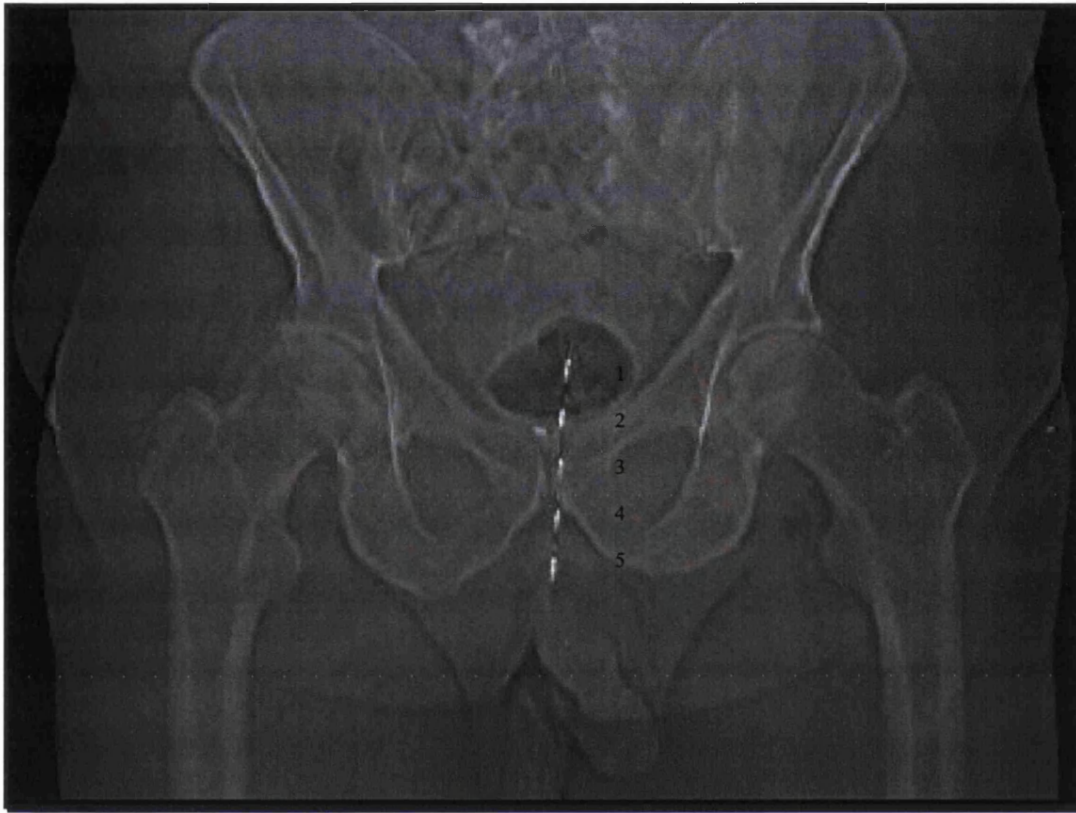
diodes position in the anorectum on CT scannogram.
